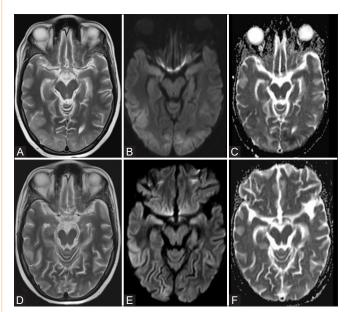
(A-F): (A-C) Images of the MR Brain on admission. (D-F) Follow-up MR images after 10 days. (A) T2 axial images showing cortical thickening with symmetric subcortical hyperintensities in the bilateral temporo-occipital lobes. (B) Diffusion weighted images showing cortical restricted diffusion in affected areas. (C) Corresponding Apparent Diffusion Coefficient (ADC) maps showing low values. (D) T2 axial images showing significant reduction in the cortical thickening. (E and F) DWI and ADC, respectively, showing near-complete resolution of the previously seen findings
